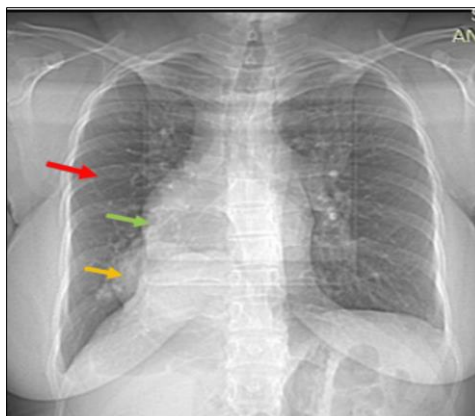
Chest X-Ray of the patient showing a hypoplastic right lung (red arrow), displacement of the heart to the right side (green arrow), and a right retro cardiac opacity (orange arrow)
